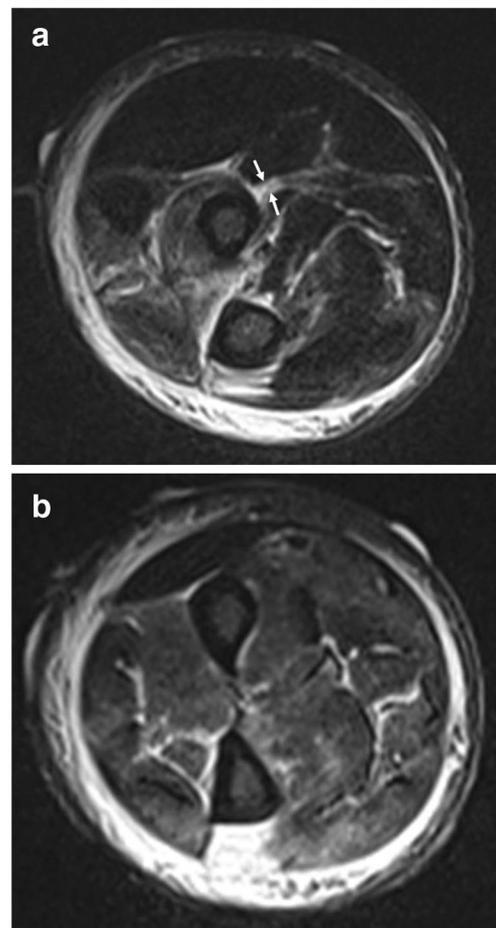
A 51-year-old male with necrotizing fasciitis. a Axial fat-suppressed T2-weighted image of the right forearm demonstrates thickening of intermuscular deep fascia. b Another axial image distal to (a) demonstrates multi-compartmental involvement of the forearm. The LRINEC score was 5, which did not indicate a high risk of necrotizing fasciitis. However, the total score using the new scoring system was 9 (thickening of intermuscular deep fascia ≥ 3 mm [1.5 points] + multi-compartmental involvement [2.5 points] + LRINEC score [5 points]), with a predicted probability of 97.5% for necrotizing fasciitis
